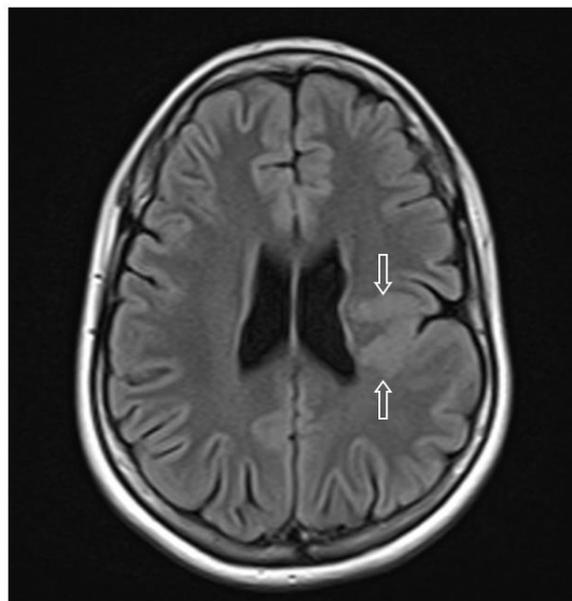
Cerebral MRI: axial section in T2 Flair-weighted sequence showing focal thickening of the left parietal cerebral cortex with hypersignal and white matter (arrows) extending from the white matter-gray matter junction to the ventricle
